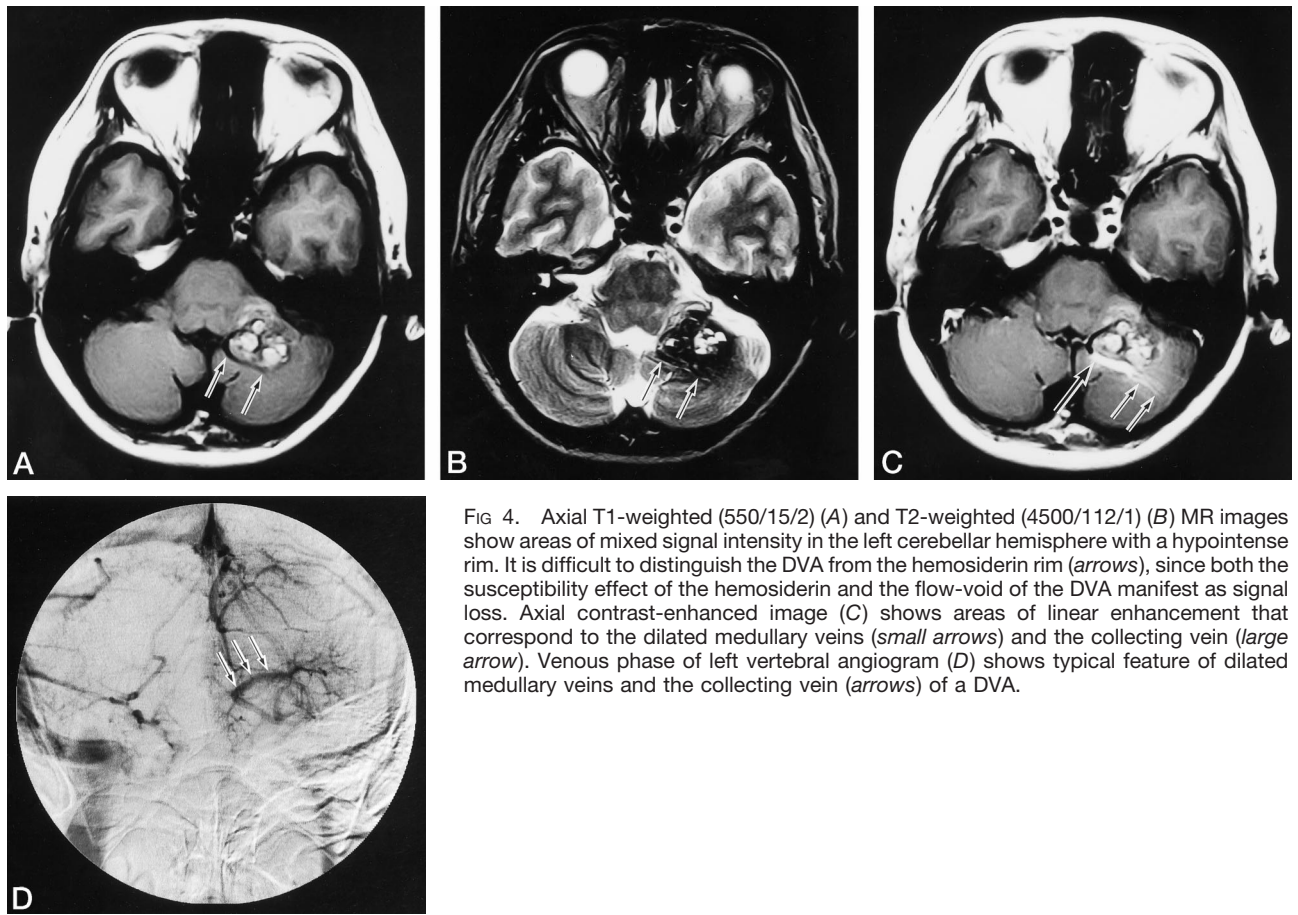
Axial T1-weighted (550/15/2) (A) and T2-weighted (4500/112/1) (B) MR images show areas of mixed signal intensity in the left cerebellar hemisphere with a hypointense rim. It is difficult to distinguish the DVA from the hemosiderin rim (arrows), since both the susceptibility effect of the hemosiderin and the flow-void of the DVA manifest as signal loss. Axial contrast-enhanced image (C) shows areas of linear enhancement that correspond to the dilated medullary veins (small arrows) and the collecting vein (large arrow). Venous phase of left vertebral angiogram (D) shows typical features of dilated medullary veins and the collecting vein (arrows) of a DVA.
